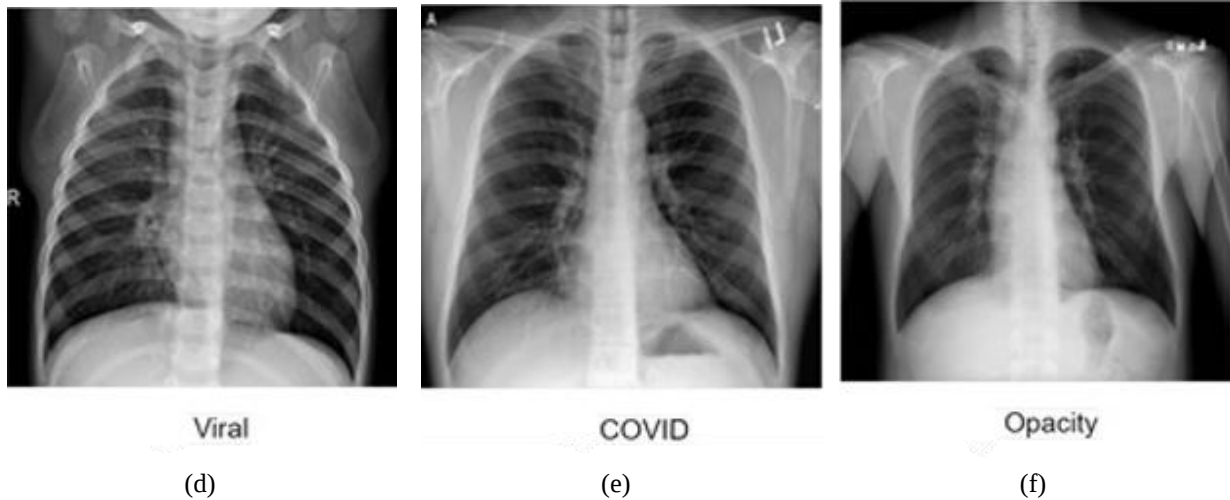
Representative chest X-ray samples from the compiled dataset.
